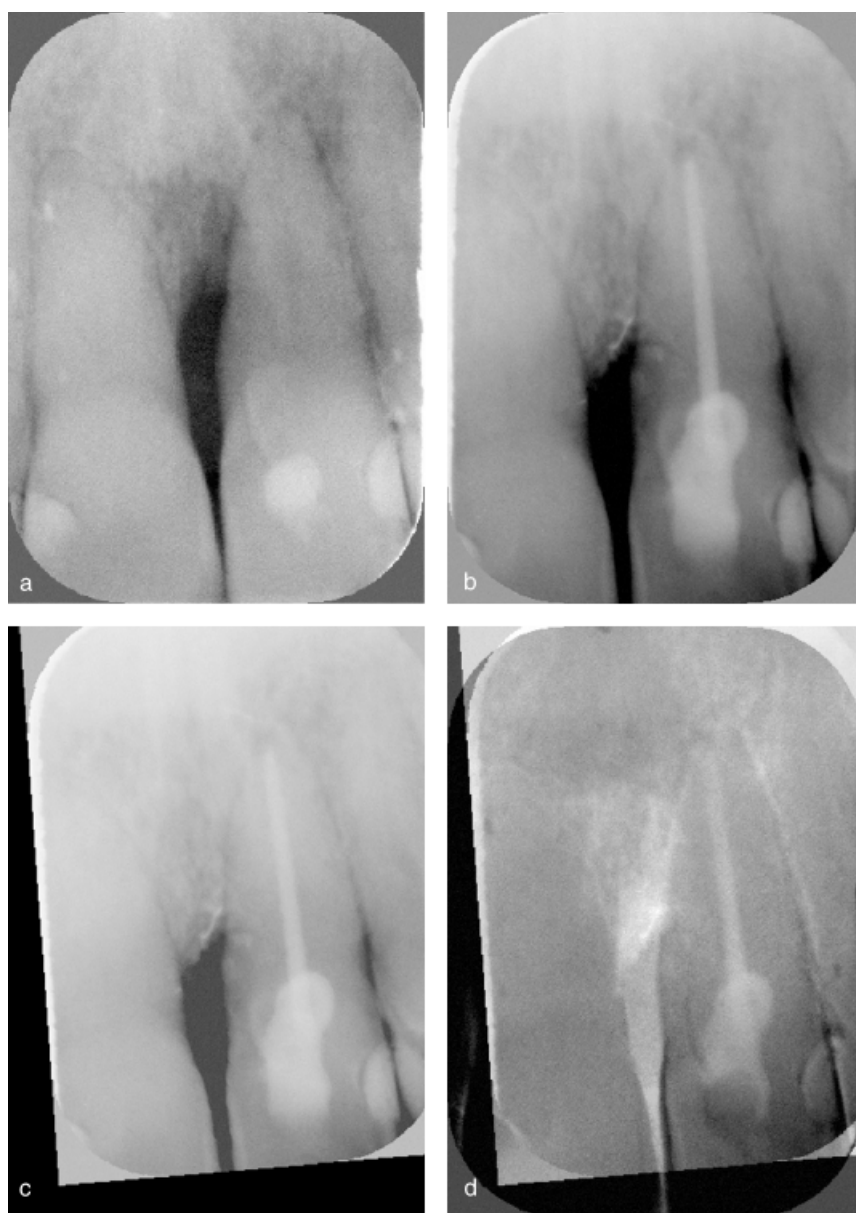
Standardized radiographs obtained at baseline showing an intrabony defect at tooth 21 (a) and 12 months posttreatment (b). Reconstructed image of the posttreatment radiograph (c). Subtraction image (d). New bone formation is indicated by the white area.
